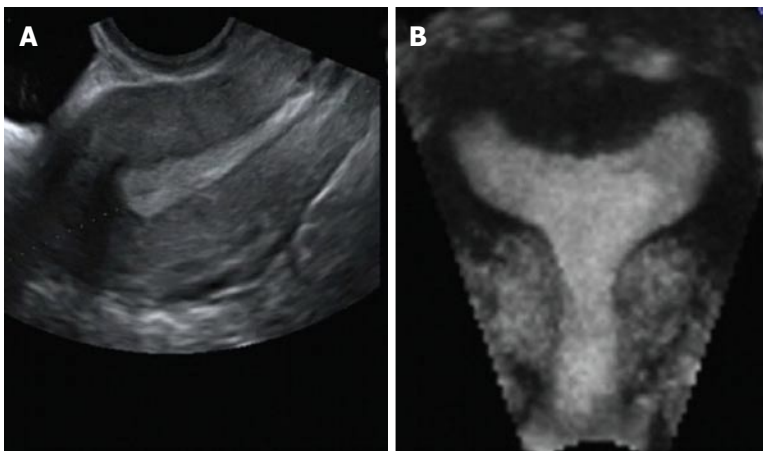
Arcuate uterus. A: Sagittal 2D ultrasound image of an arcuate uterus; B: Coronal 3D ultrasound image of an arcuate uterus with a smooth external contour and internal indentation ≥ 1 cm but ≤ 1.5 cm. 3D: Three-dimensional; 2D: Two-dimensional.
